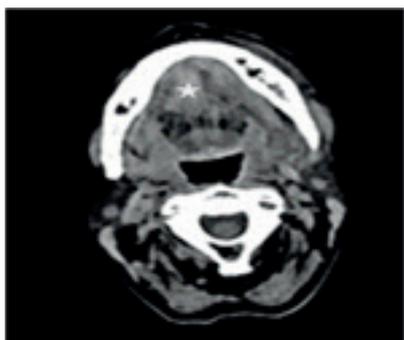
Axial non-contrast computed tomography scan shows hyperdense lesion compatible with hematoma at the level of the genioglossus muscle.
